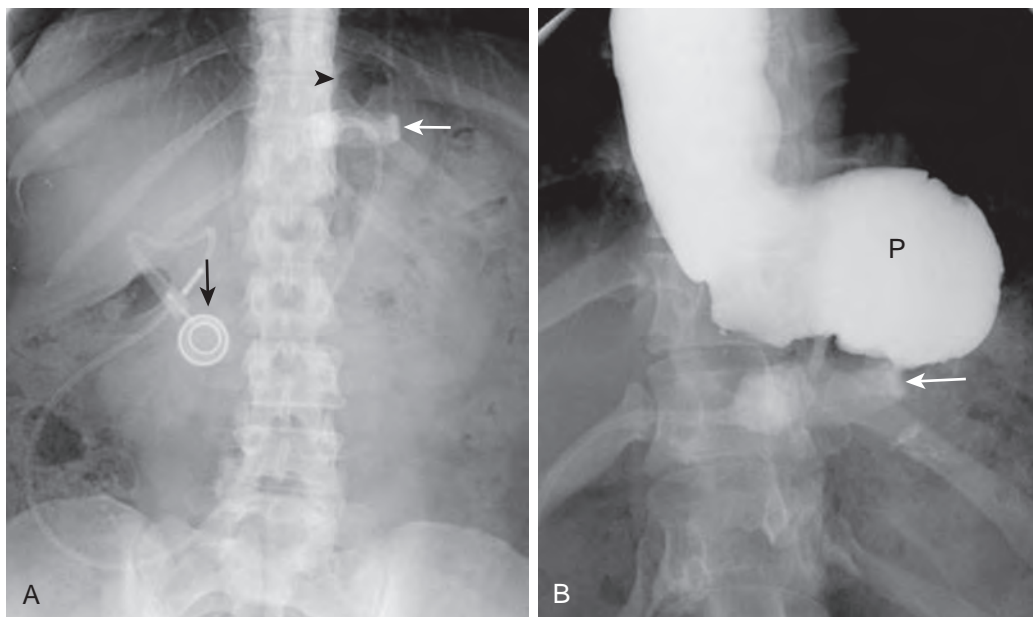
Band slippage following LAGB. A. Supine radiograph in the same patient as in Figure 35-22 1 year later shows a change in the configuration of the band (white arrow) (see Fig. 35-22B). It is now inferiorly located and horizontal in configuration. There is a dilated, gas-filled stomach bubble superior to the band (arrowhead). The port (black arrow) is relatively unchanged. B. UGI image shows an eccentrically dilated gastric pouch (P) above the horizontal band (arrow), with obstruction at the level of the band caused by band slippage. The esophagus is also dilated.
